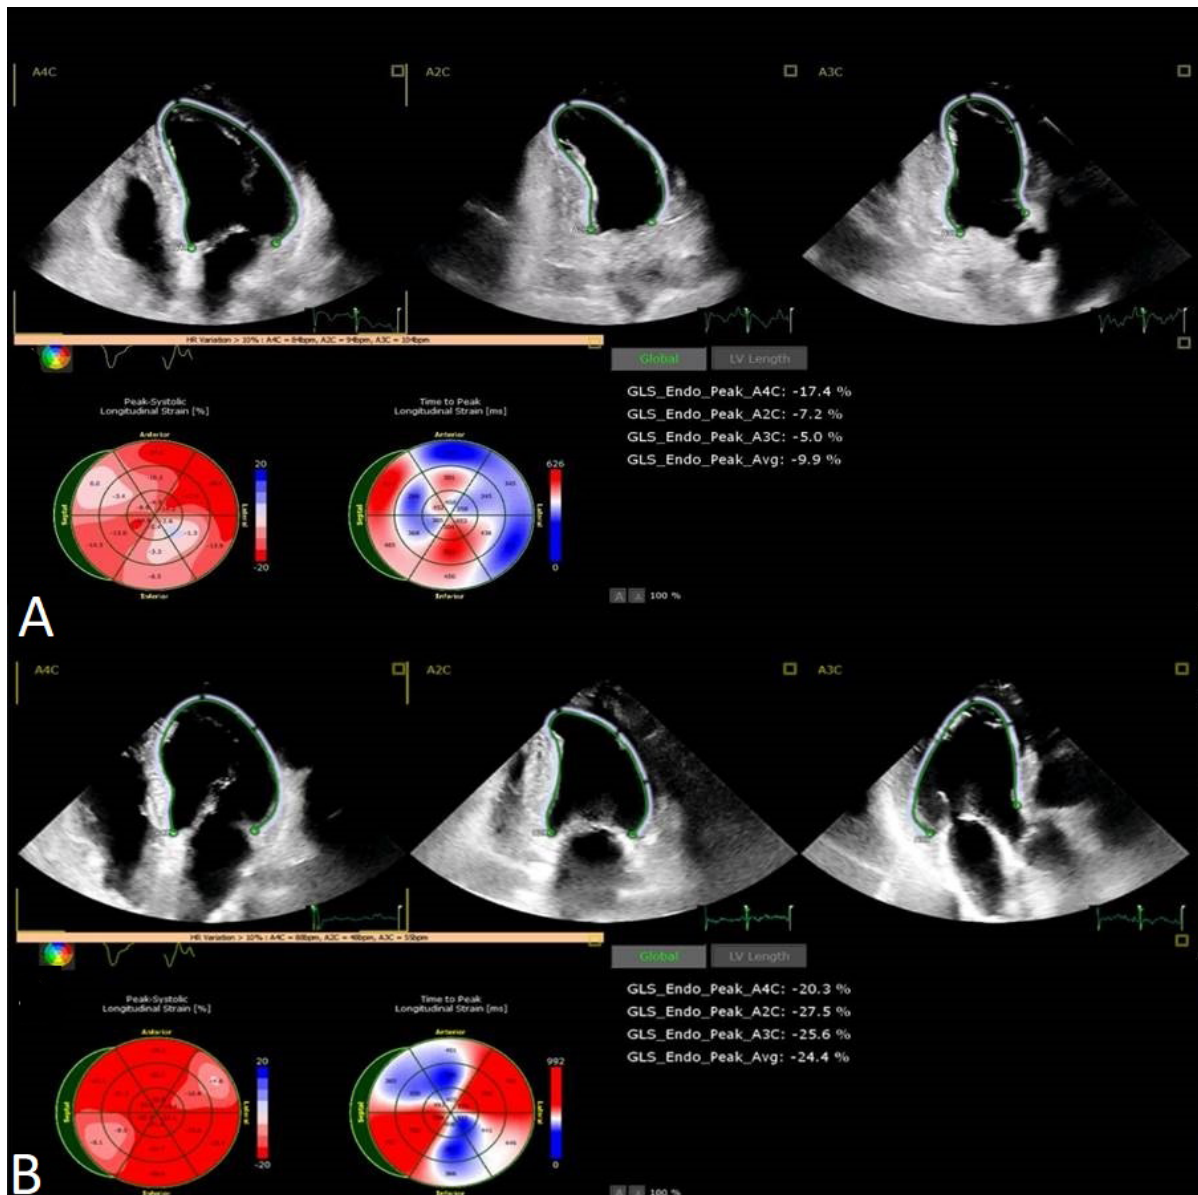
Speckle tracking echocardiography showing the improvement in global longitudinal strain and time to peak longitudinal strain from the acute phase (A) to 1 month follow-up (B). GLS, global longitudinal strain.
